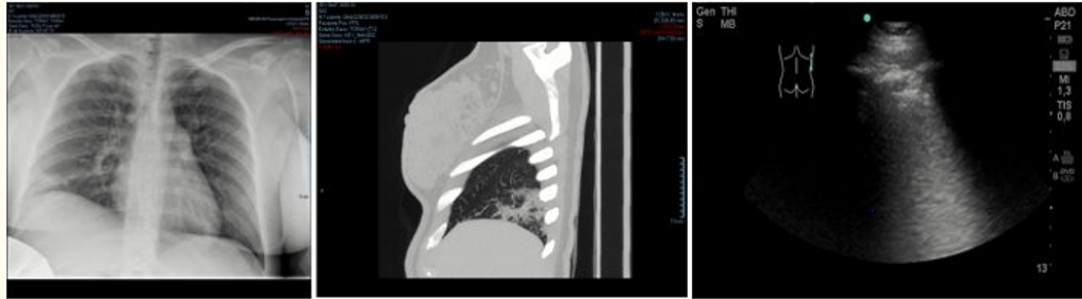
Comparison of chest radiography, chest CT and lung ultrasound that shows lung consolidation in right basal on paravertebral line, complete loss of aeration. LUSS 3.
